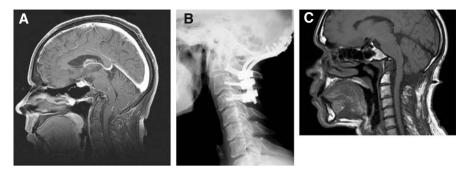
A This sagittal T1-weighted MRI demonstrates a combination of basilar invagination and Chiari I malformation in a 43-year old man with a 3-year history of occipital pain, gait ataxia and swallowing problems. Due to the significant anterior compression in this patient, a combined surgical approach with transoral resection of the odontoid followed by foramen magnum decompression and craniospinal fusion C0 to C4 was chosen. B The postoperative lateral X-ray shows the instrumentation with lateral mass fixation with a good sagittal profile of the cervical spine. C The postoperative MRI after 6 months shows a good ventral decompression and a free CSF passage at the foramen magnum. The patient reported improvements of swallowing and occipital pain. The slight gait ataxia has persisted
